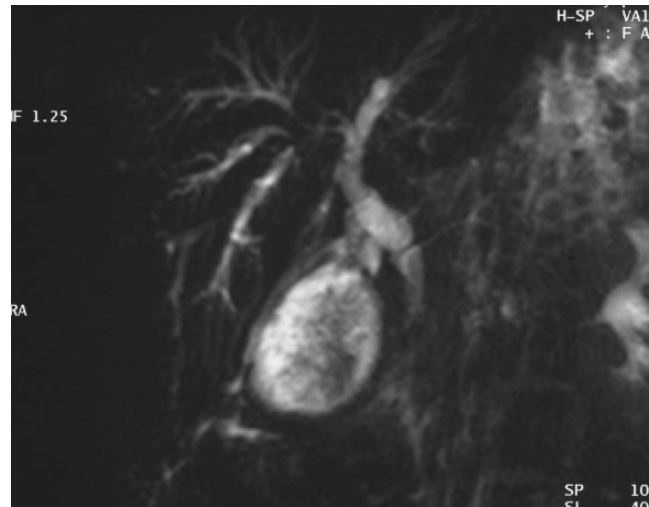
Magnetic resonance imaging is less invasive than endoscopic retrograde cholangiopancreatography and demonstrates the characteristic features of an enlarged gallbladder, with irregularity of the intrahepatic ducts due to septal dilation and short strictures.
